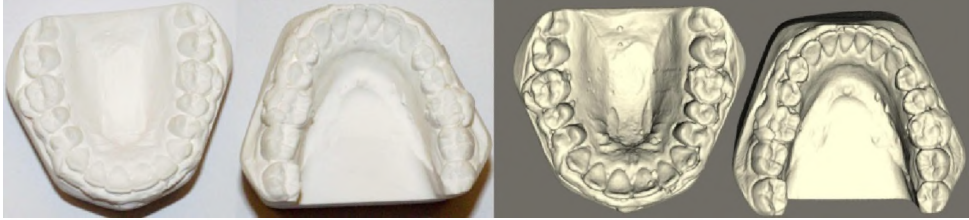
To obtain digital dental models, plaster cast were separately CBCT scanned.
